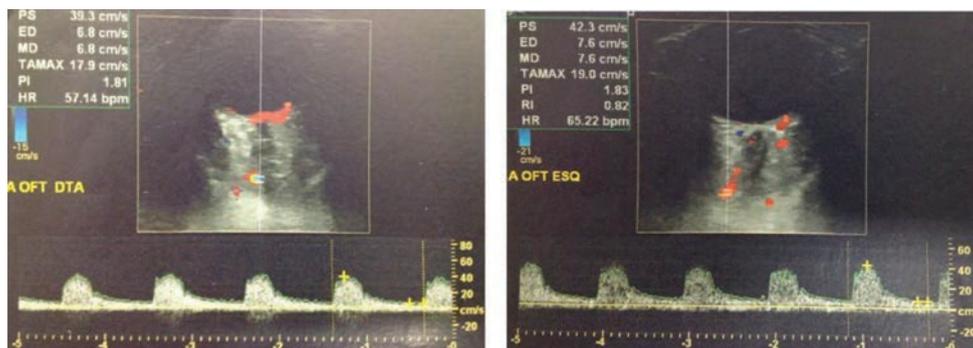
Ophthalmic Doppler of the right and left ophthalmic artery (before stent intervention).
